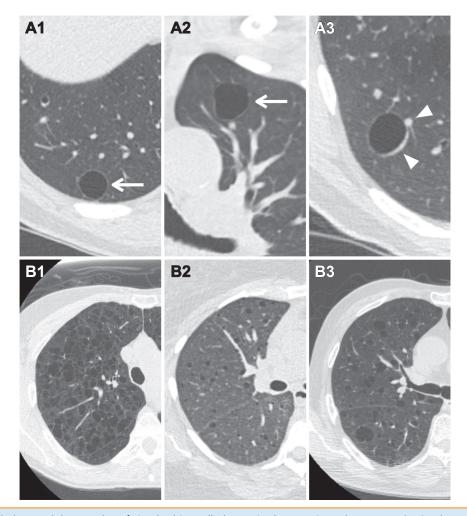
Thin-walled cysts. (A) Examples of simple thin-walled cysts in three patients (A1, A2, A3). Simple cysts are unilocular with a wall thickness < 2 mm (arrows) and are not classified or managed in Lung CT Screening Reporting and Data System (Lung-RADS). Care should be taken to avoid mistaking vessels (arrowheads) with nodules or wall thickening. (B) Three patients with cystic lung disease: lymphangioleiomyomatosis (B1), Langerhans cell histiocytosis (B2), and lymphocytic interstitial pneumonia (B3). Multicystic lung disease is not classified or managed in Lung-RADS unless a cyst is identified with atypical features (eg, multilocular, thick-wall, associated nodularity).
